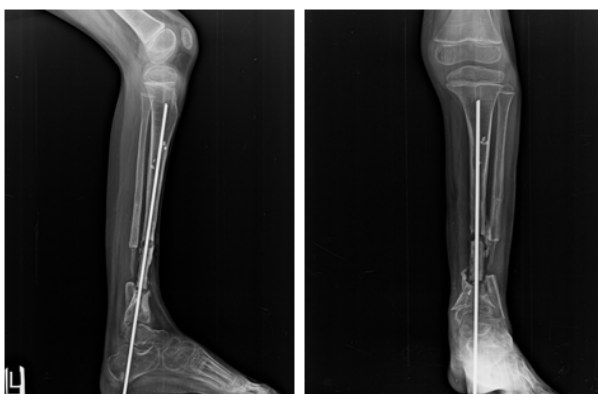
X-ray showing presentation at follow up after 2 months
